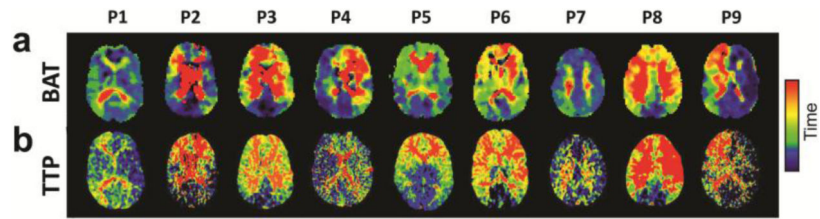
Qualitative comparison of the BAT maps obtained from the MRI scan and the TTP maps obtained from the CTP scan.
